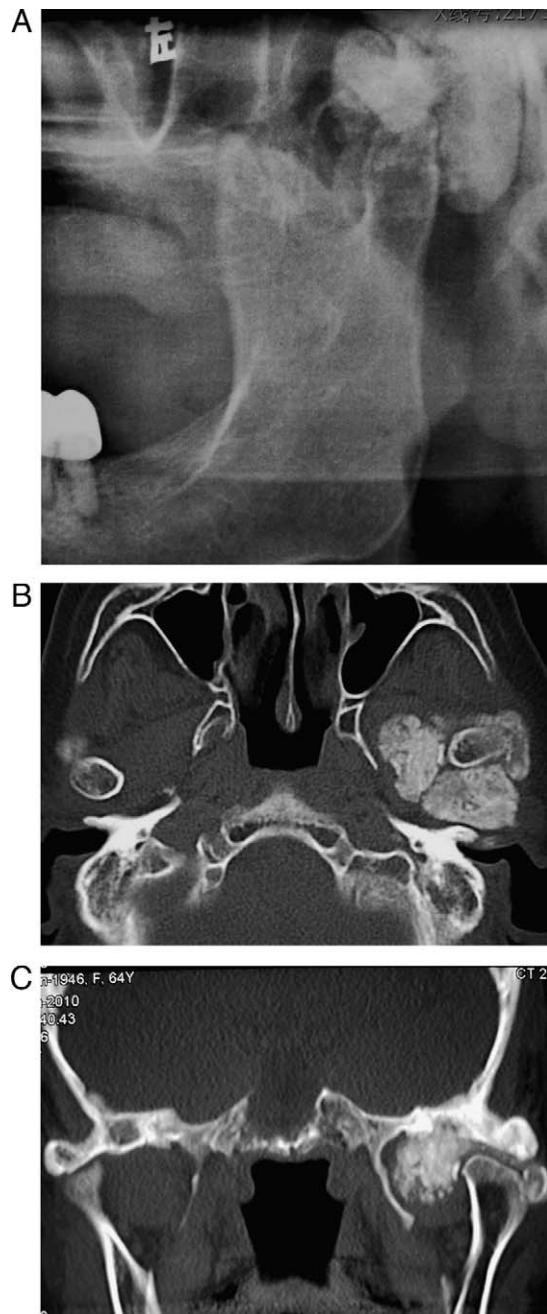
(A) Panoramic image showing three large masses with gravel-like appearance and calcified foci in the left joint region. The glenoid fossa was destructive. (B) Axial CT scan showing a few granular calcified masses surrounding the left condylar head, and extending into the infratemporal fossa. (C) Coronal CT scan revealing calcified mass in the joint space. Destruction and sclerosis of the middle cranial base were present and the lesion seemed to extend into the middle cranial fossa.
